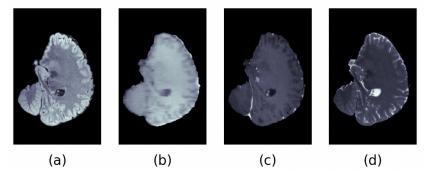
Different types of sequences in brain MRI: (a) Flair; (b) T1; (c) T1ce; (d) T2
